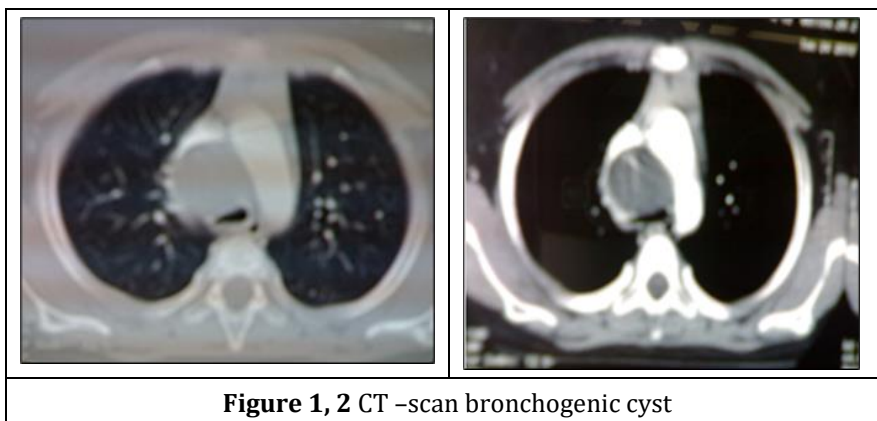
2 CT –scan bronchogenic cyst
